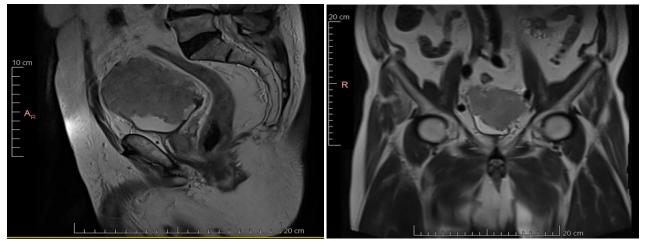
Magnetic Resonance Imaging (MRI) scans (Siemens 1.5T, Magnetom, Erlangen, Germany) demonstrated huge mass involving especially the superior wall and the other walls of the urinary bladder (T2W images, sagittal plane on left; Coronal plane on right)
